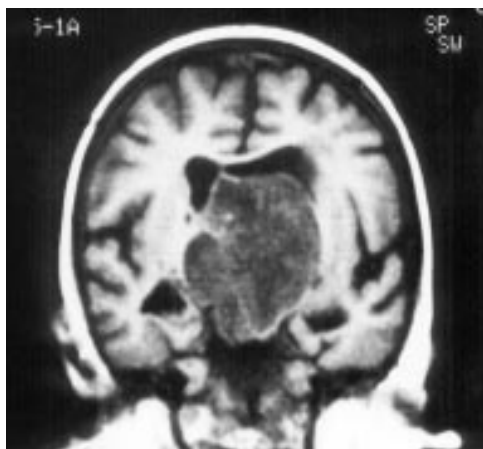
MRI, coronal cut, T1 weighted (600/27). Large suprasellar and hypothalamic solid mass, compatible with hypothalamic/chiasmatic glioma.
